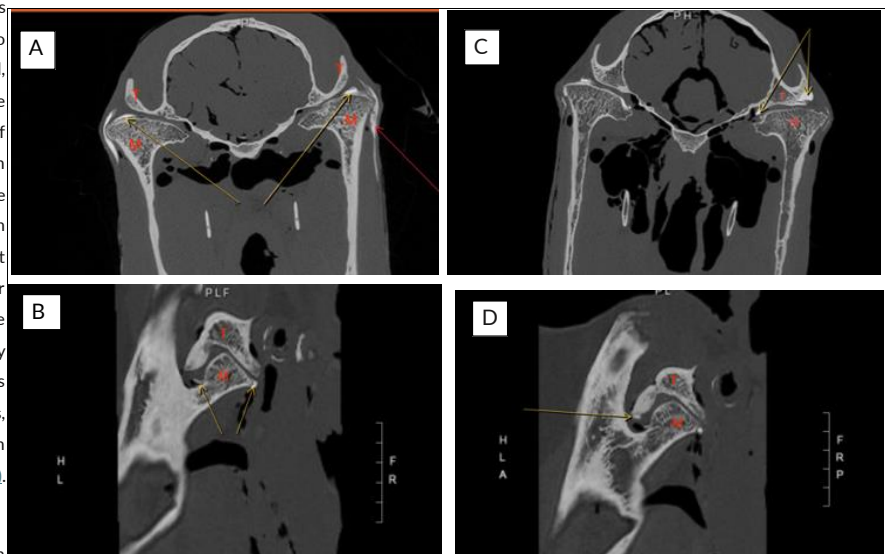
Four CT scans: (A) a coronal view of the right and left TMJ with contrast in the DMJ, (B) a sagittal view of the left TMJ with contrast in the DMJ, (C) a coronal view of the right and left TMJ with contrast that communicates into the DTJ, (D) a sagittal view of the left TMJ with contrast that communicates into the DTJ. (A, B) Yellow arrows point to contrast in the DMJ. Red arrow points to extraarticular contrast that is subcutaneous. (C, D) Yellow arrows point to contrast in the DTJ. M - Mandibular condyle, T - Temporal bone.
